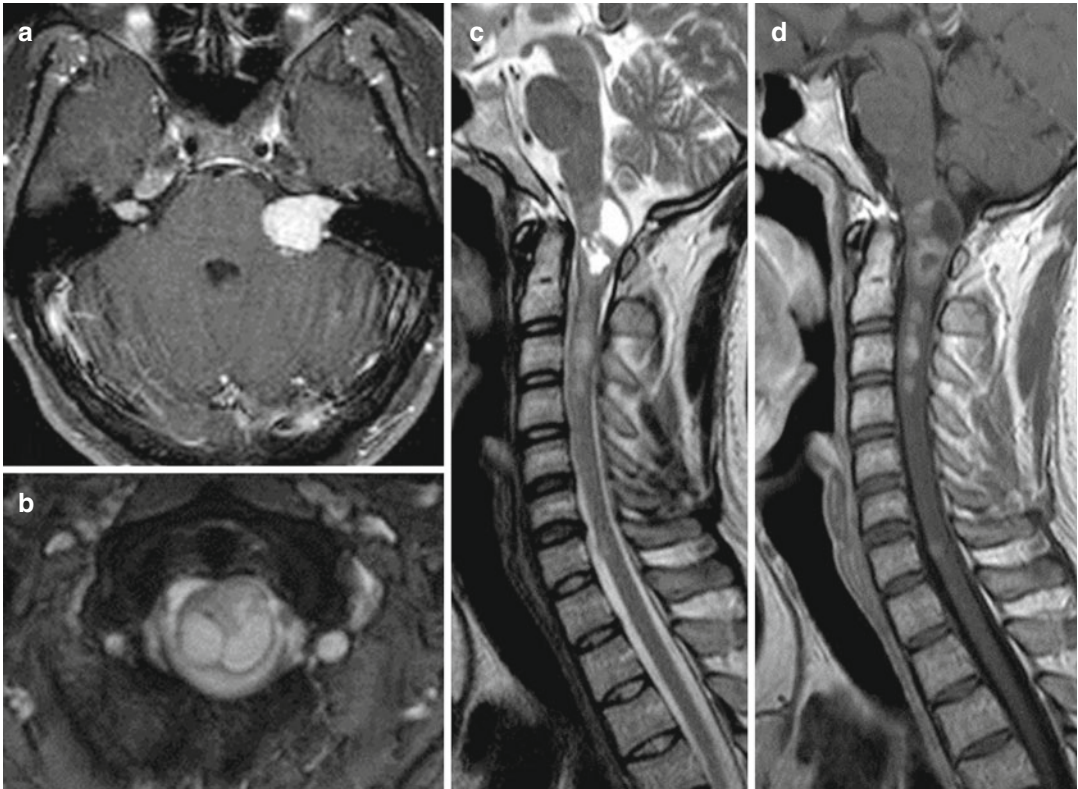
NF2. Axial T1-weighted image after contrast medium (a) shows bilateral asymmetric schwannomas of both VIII cranial nerves. Axial T2- (b) and sagittal T2-weighted image and sagittal T1-weighted image after
